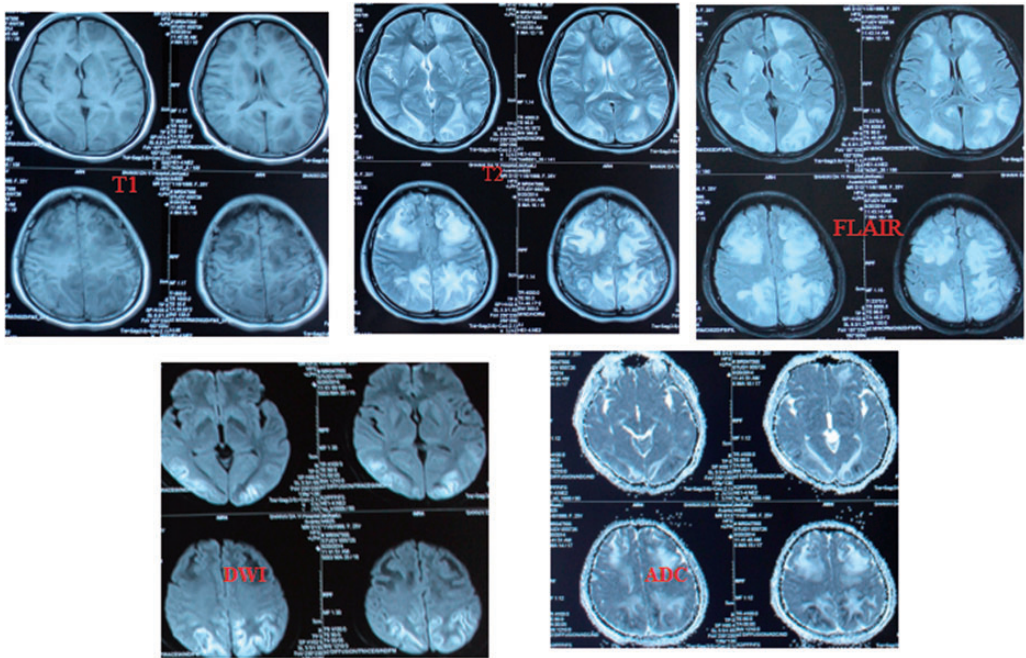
Magnetic resonance imaging results obtained on 20 June 2014. a. T1-weighted image. b. T2-weighted image. c. fluid-attenuated inversion recovery image. d. diffusion-weighted image. e. apparent diffusion coefficient
